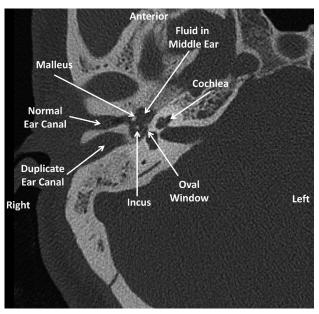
Axial CT image of the right temporal bones at the level of the cochlea demonstrating duplicate ear canal with the bony wall separating the two canals.
